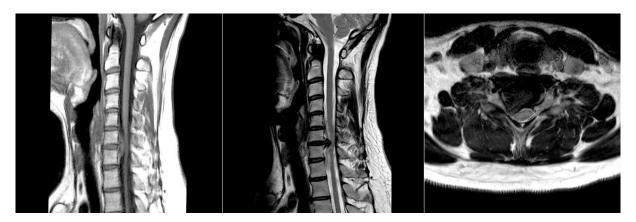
Left and middle inset: sagittal MRI images of cervical spine showing a disc hernia at the C6-7 level; Right inset: axial image of the cervical MRI spine at the above level.
